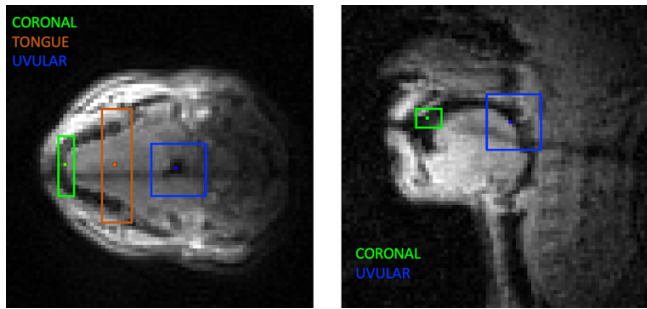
Regions of interest (ROI) for the oblique and mid-sagittal MRI slices.
